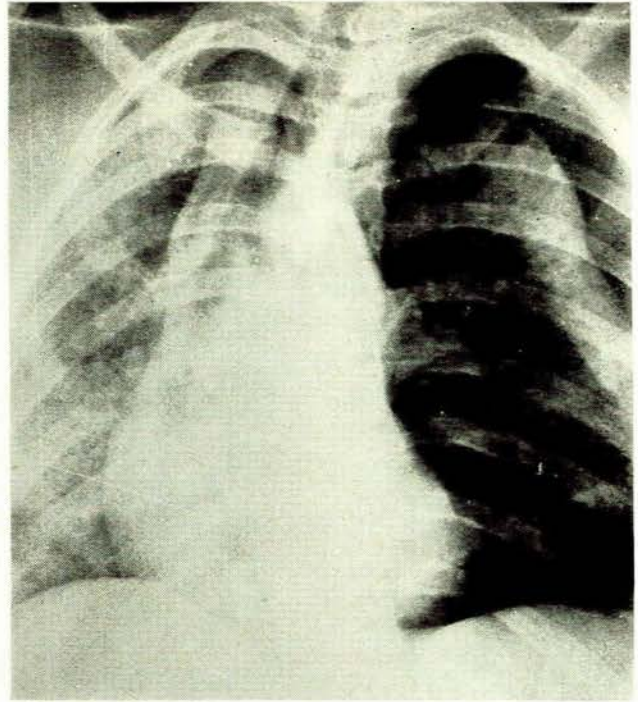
Chest X-ray on admission showing left-sided pneumothorax and an intact thoracic cage.
